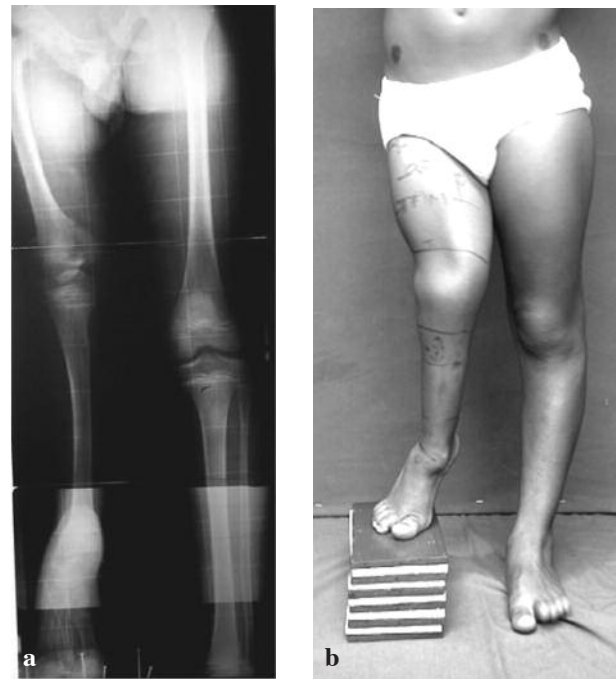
(a) Preoperative radiograph of a 13-year-old boy showing shortening and deformity associated with proximal focal femoral deficiency ; (b) Preoperative clinical picture of the same patient.
